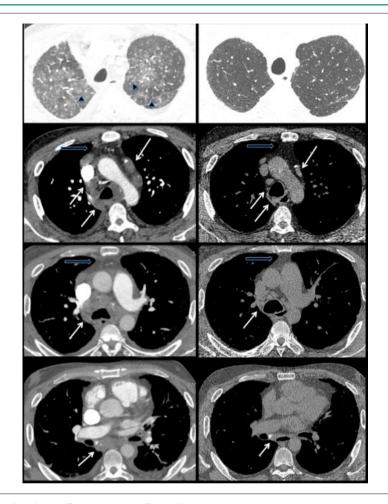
Chest HRCT revealing bilateral diffuse ground-glass infiltrate with superior lobes predominance, interlobular septal thickening (black arrowheads) and small pleural effusion bilaterally, without arterial trombi. Enlarged lymph nodes are noticed in the paraaortic, paratracheal and subcarinal regions, some with peripheral calcification (white arrows). On the right: Chest HRCT performed two months later shows resolution of ground glass opacities and septal thickening, and involution of mediastinal lymphadenomegaly (white arrows) and mediastinal fat (black arrows). The nephrotic syndrome causing hypoalbuminemia, low plasma colloid osmotic pressure and augmented transcapillary fluid leakage was the probable cause of the radiological findings.
